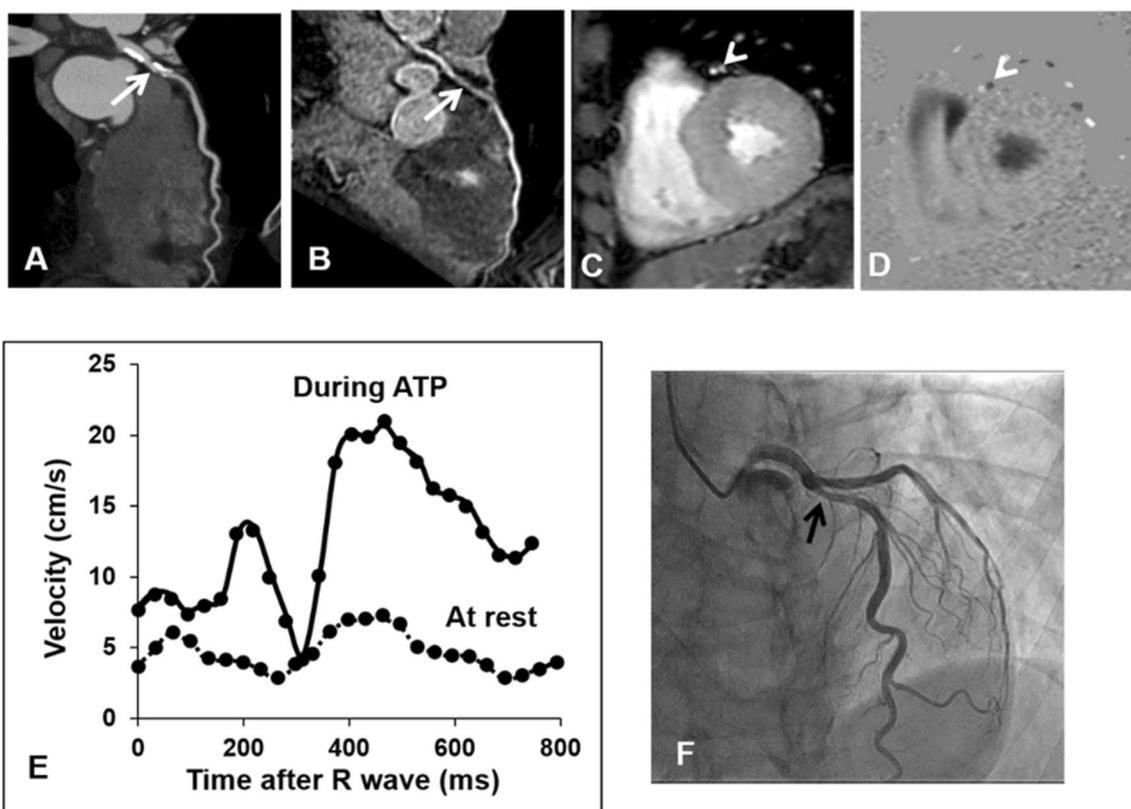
(vessel case 10) In a 75-year old man with Agastston score of 1177, moderate stenosis was suspected in the proximal LAD on CT angiography and MR angiography (a, b). Magnitude image (c) and phase contrast image (d) of the LAD artery distal to the lesion.
